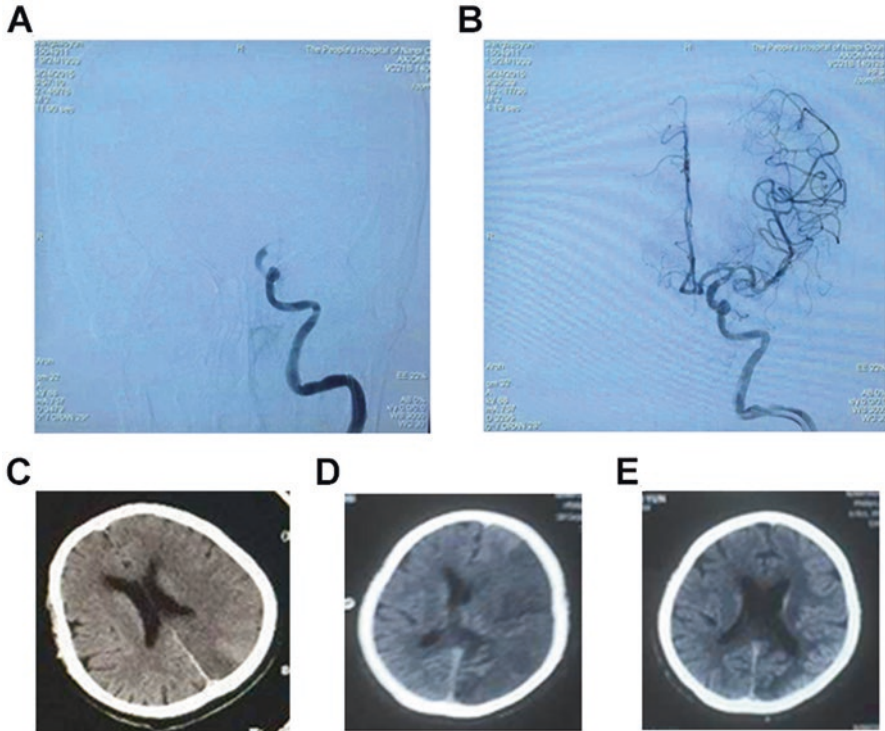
Case V: infarction is reversible even after days. Female middle cerebral artery occlusion patient, 76-year-old, head computed tomography (CT) showed no infarction at the first day (a, c). Then thrombolectomy surgery was successfully performed and clots were retrieved (b, c), but the patient was still in coma. On day 7, head CT reexamination showed large low density existed (d), but this patient recover consciousness at day 12, then CT on day 14 showed the infarction area significantly reduced (e) and the patient awaked with aphasia
